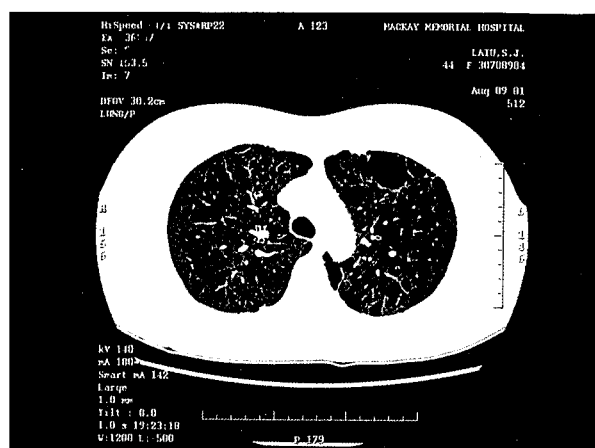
HRCT showing multiple thin walled cysts evenly distributed throughout the lung fields; the intervening parenchyma appears normal.
